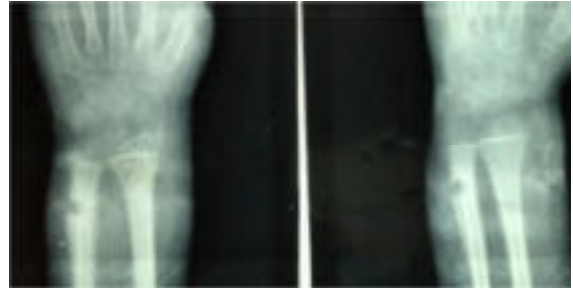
AP (a) & lateral (b) X-rays at presentation showing osteomyelitis of both distal ulna & radius, with periosteal reaction and lytic lesion on medial side of ulna and radial side of radius.
